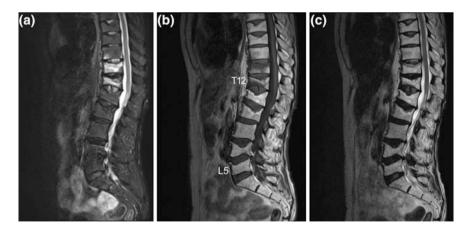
Sagittal a short tau inversion recovery (STIR), b T1-weighted, and c T2-weighted MRI sequences of the thoracic and lumbar spine. Note the presence of bone marrow edema (hyperintense STIR and hypointense T1 signal, respectively) in T11 and T12 as well as close to the lower endplate in T10 as indication for recent osteoporotic vertebral fractures. In contrast, note the absence of bone marrow edema in the old osteoporotic vertebral fractures of T8, T9, L1, L2, L4, and L5
